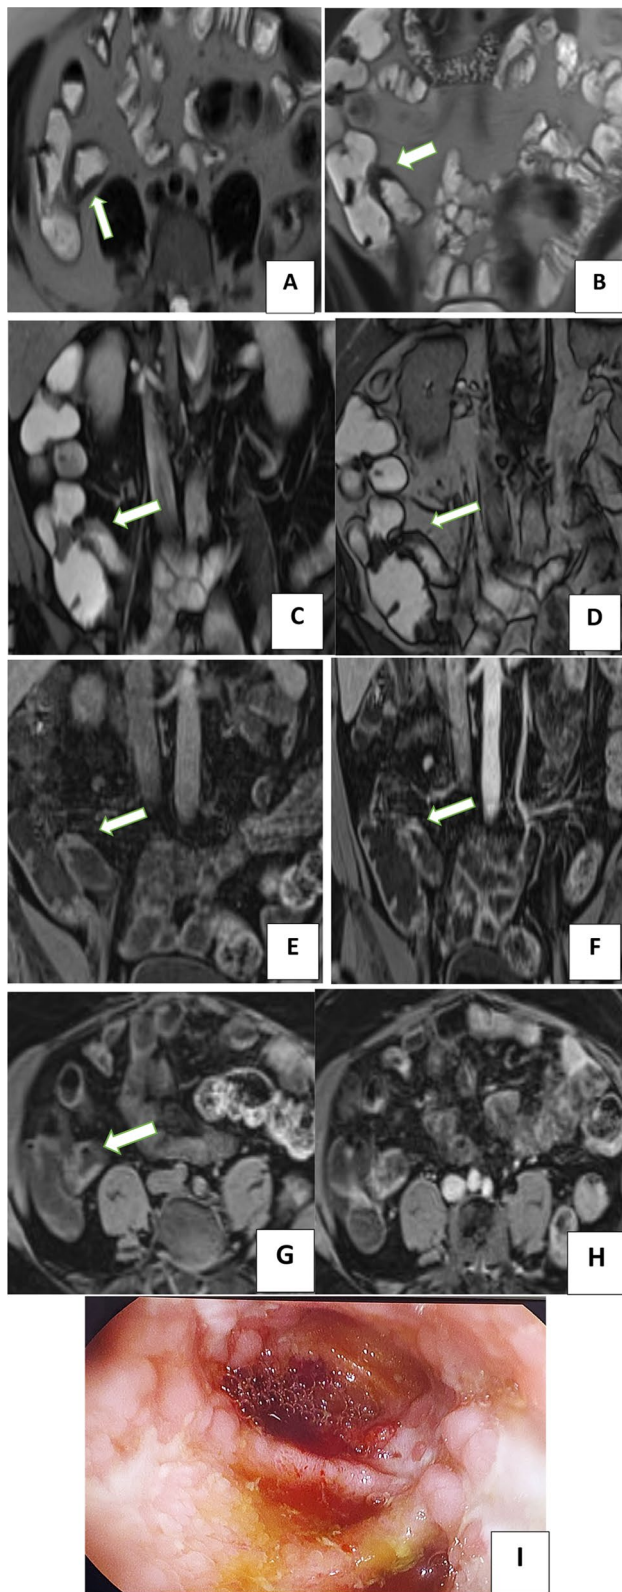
(Case 1): A 39-year-old male patient, presented with persistent diarrhea and weight loss, ultrasound performed was free, MRE was performed. Axial and coronal T2 Haste (half-Fourier acquisition single-shot turbo spin-echo) images A, B show circumferential mural wall thickening at the distal ileum with stricture formation at the ileo-caecal junction (white arrows), coronal T2 Haste (half-Fourier acquisition single-shot turbo spin-echo) FAT SAT image (arrow) C, coronal TRUFI: true fast imaging with steady-state free precession with FS D, coronal T1 vibe Dixon pre-contrast and post-contrast images with FS E, F show enhancement of the distal ileum with stricture formation as well as mid-ileal loops with enhanced thickened walls (skip lesions), few enhancing reactive mesenteric lymphnodes are seen, axial T1 vibe Dixon pre-contrast and post-contrast images G, H show thickening of distal and mid ileal loops. Ileo-colonoscopy image I showed severe hyperemia, inflammation, thickening, wall thickening and irregularities with multiple ulcerations of terminal ileum. Laboratory investigations & endoscopy (ileo-colonoscopy) were done by experienced gastroenterologist and confirmed the radiological diagnosis of Crohn's disease
